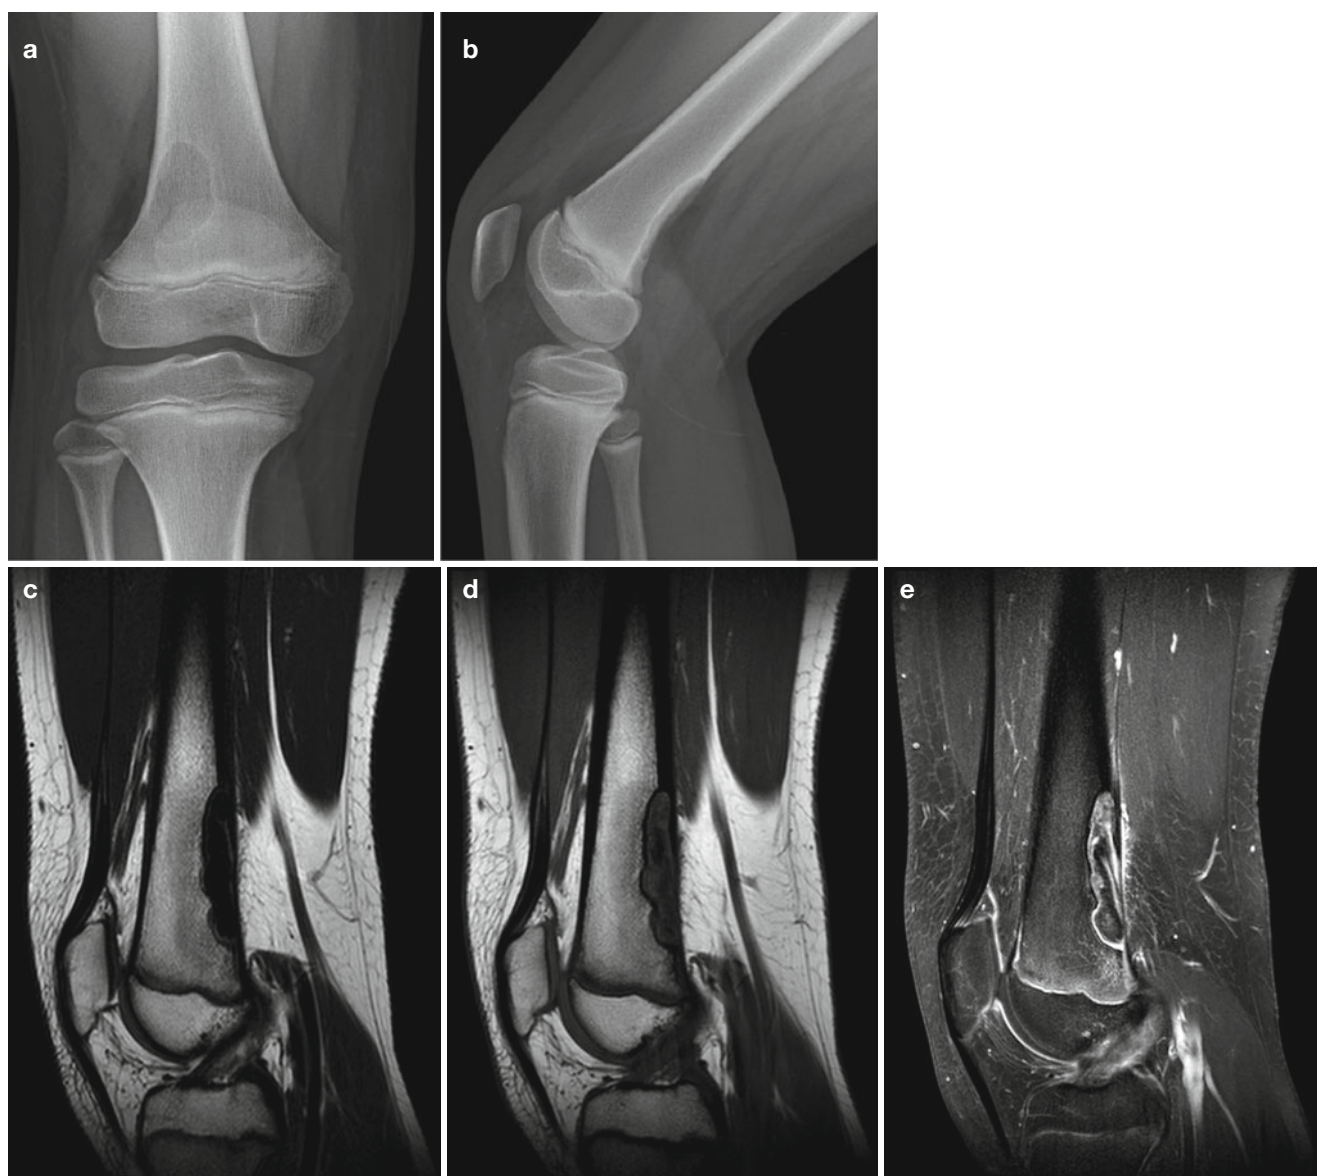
Non-ossifying fibroma in a 12-year-old boy.* (a, b) Right-knee AP (a) and lateral (b) radiographs show a well-circumscribed and elongated radiolucent bony lesion in the right distal femur which is eccentrically located at the posterior cortex. (c–e) The lesion appears
